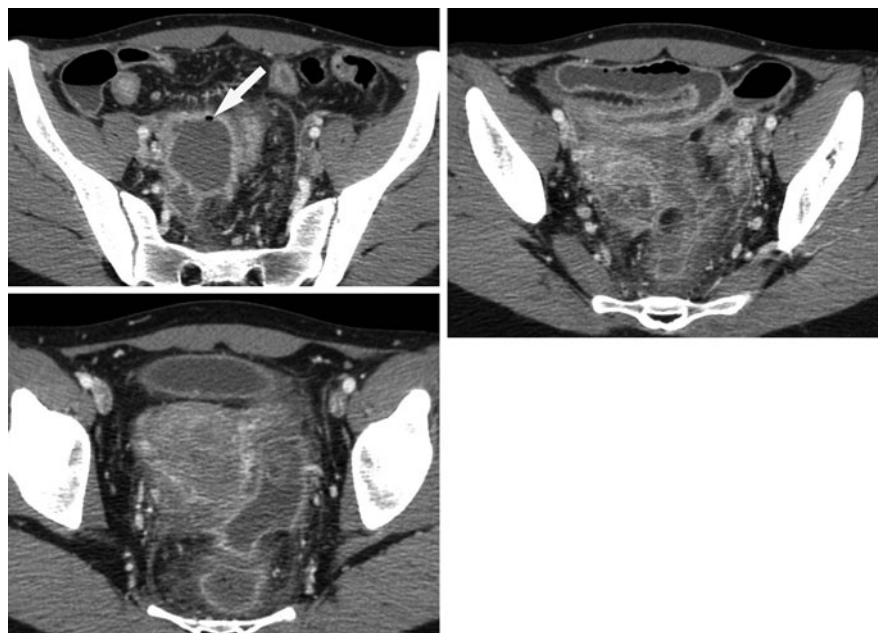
Phlegmon complicating an ileal Crohn's disease extending to the rectosigmoid junction. The CT scan shows the typical images of ileal Crohn's disease (*black arrow*). In the pelvis there is massive inflammatory infiltration of the adjacent mesenteric structures (*straight white arrow*) (a–c) with continuous extension at the rectosigmoid junction (*white curved arrow*) (d)
